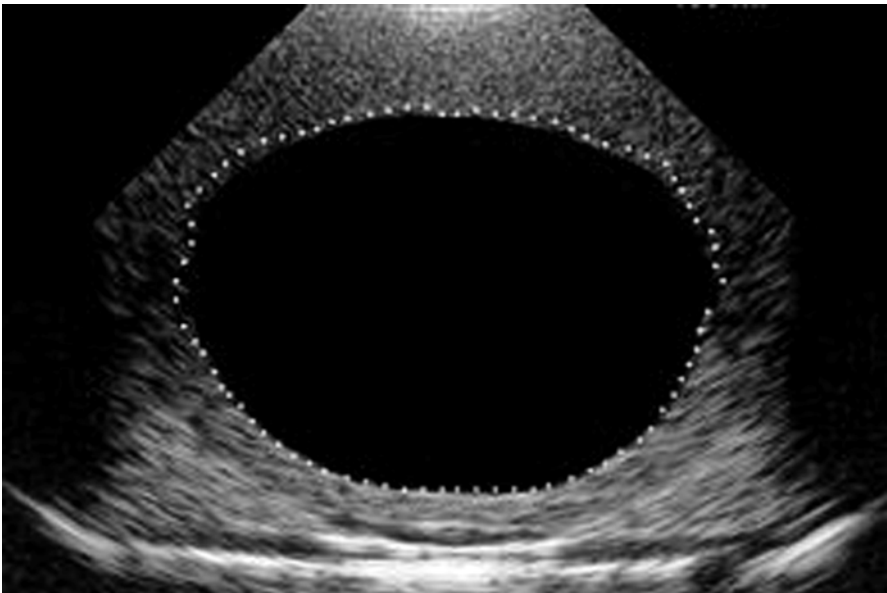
Ultrasound image of bladder being measured for PVR with bladder outlined
